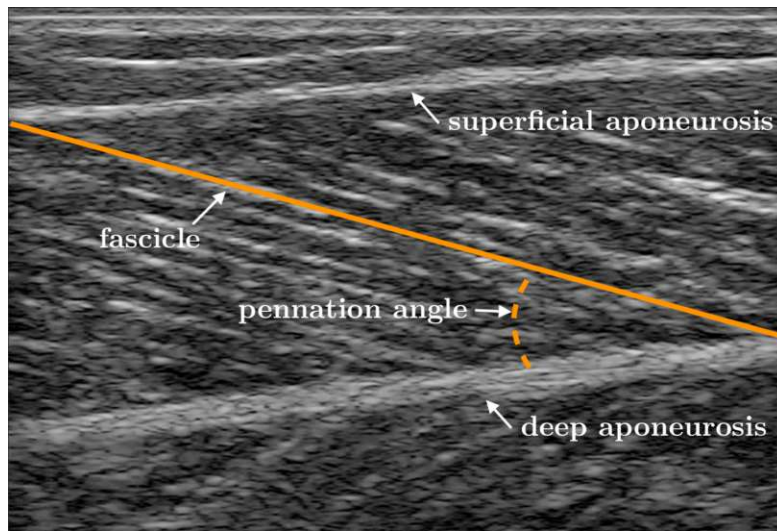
Ultrasound B-mode image with fascicle length and pennation angle.
